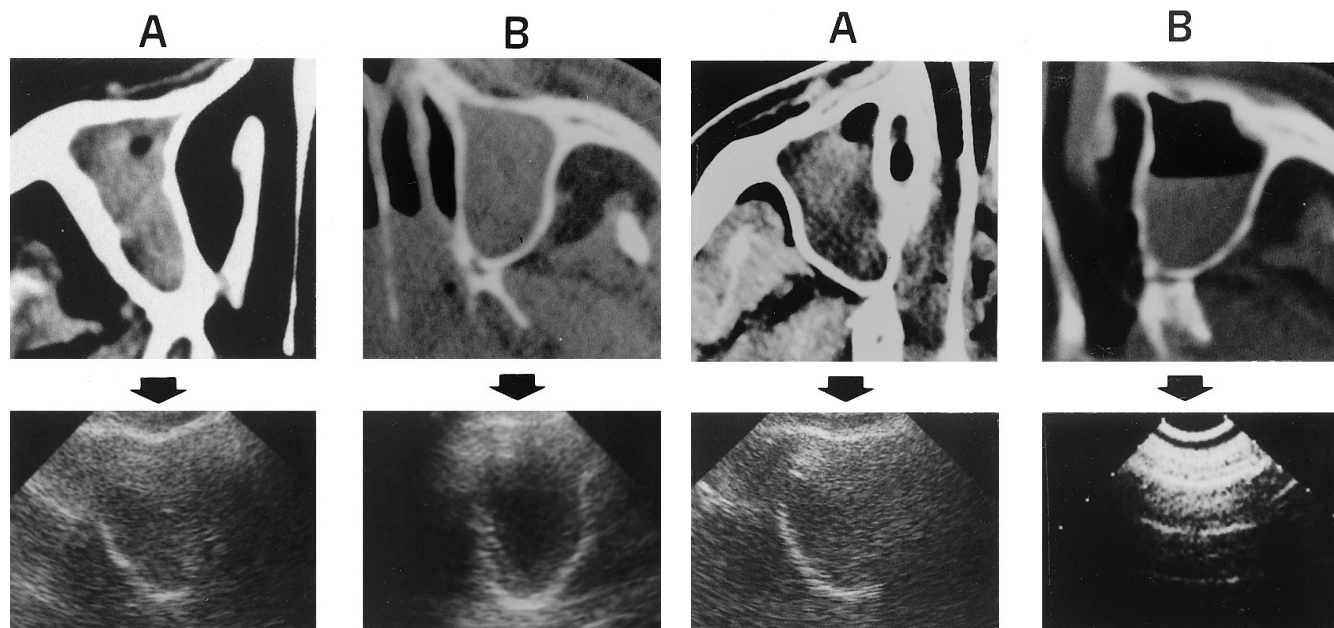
A: Total opacity of the right sinus with a small anterior air bubble (CT), associated with an incomplete "sinusogram" (ultrasound). B: total opacity of the left sinus with homogeneous pattern (CT), associated with a complete "sinusogram" (ultrasound)
